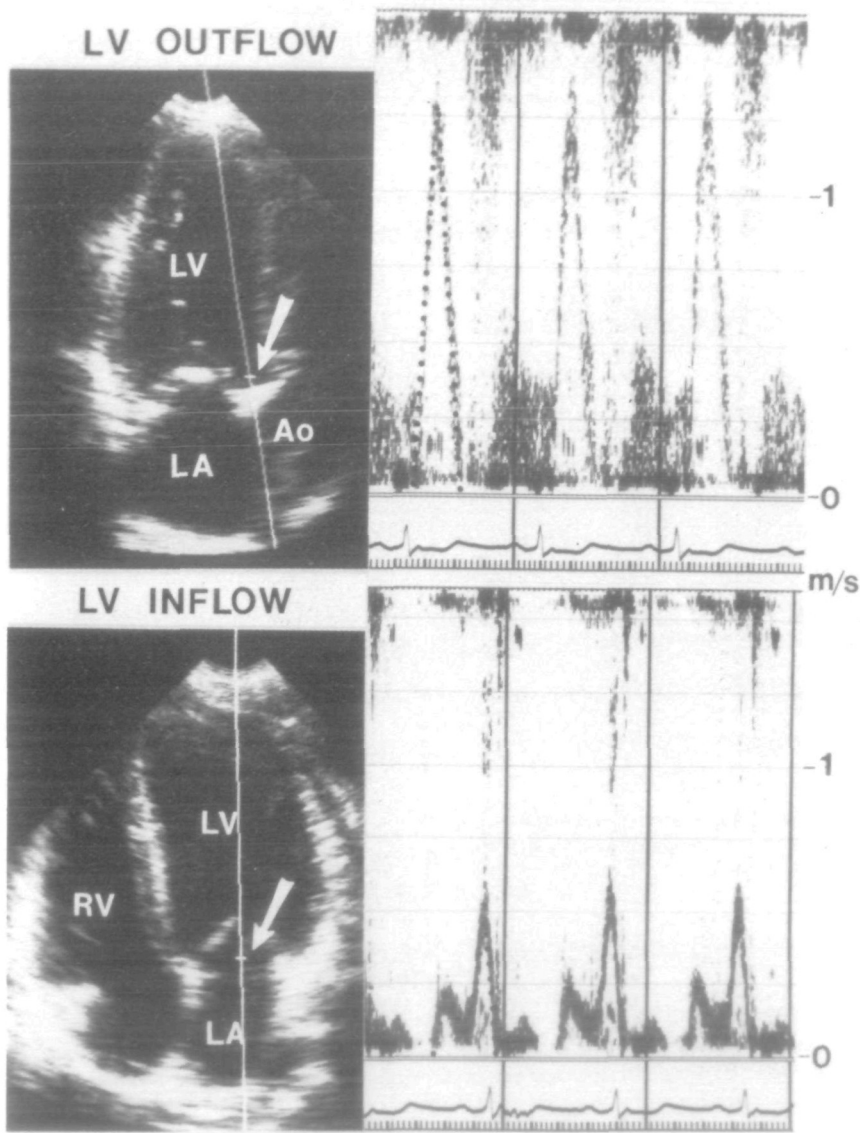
Measurement of volume flows in aortic regurgitation. Top panels—left ventricular (LV) outflow is measured from outflow tract diameter (left) and systolic flow velocity (right) to determine total flow. Bottom panels—LV inflow is measured from mitral annular diameter (left) and diastolic flow velocity (right) to determine net forward flow. In this example from a patient with aortic stenosis and mild aortic regurgitation, the Doppler regurgitant fraction was 32%.
